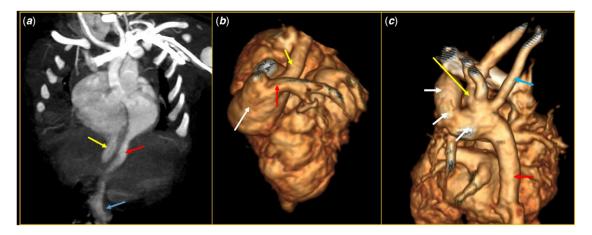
Oblique Maximum Intensity Projection (a) and 3D Volume Rendered CT angiography images. a Thick-walled left (red arrow) and right ventricular (yellow arrow) diverticula arising from apical parts of both ventrices. While right ventricular diverticulum is smaller, left ventricular diverticulum extends up to the umbilicus (blue arrow). b Crossing pulmonary arteries- the left pulmonary (red arrow) artery ostium originates from the main pulmonary artery (white arrow) above and to the right of the right pulmonary artery (yellow arrow). c Large patent ductus arteriosus (white arrows), right-sided descendent aorta (red arrow), the aberrant course of the right subclavian artery (blue arrow) and left sided arcus aorta (yellow arrow) are shown.
